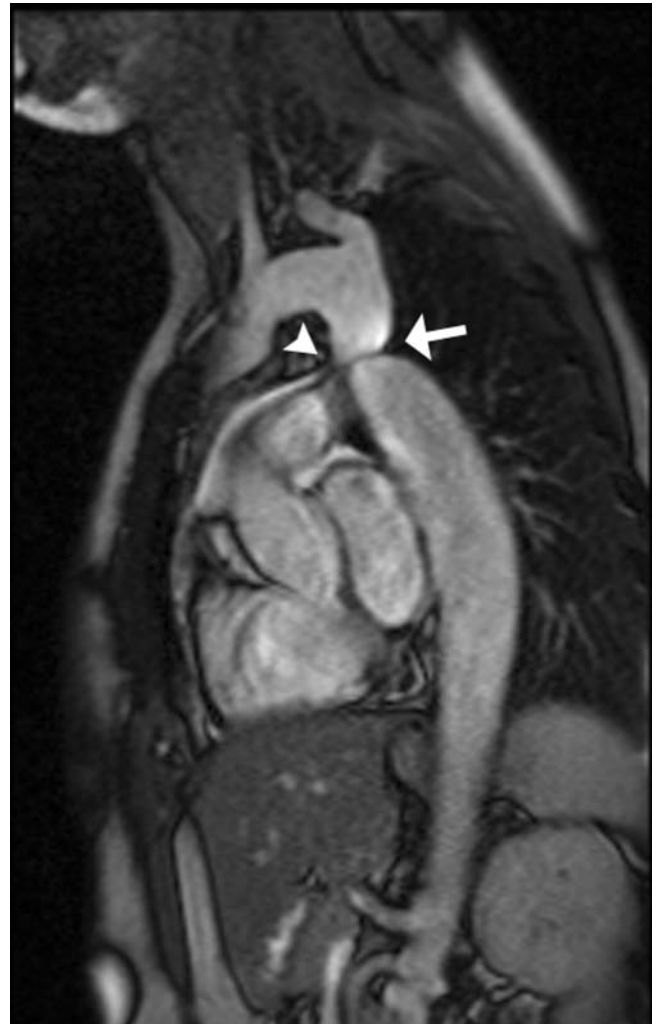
A 25-year-old male presented with claudication on running. A sagittal fast imaging with steady-state precession (FISP) magnetic resonance image of the thoracic aorta demonstrates a coarctation (arrow) and a persistent patent ductus arteriosus (arrowhead).
